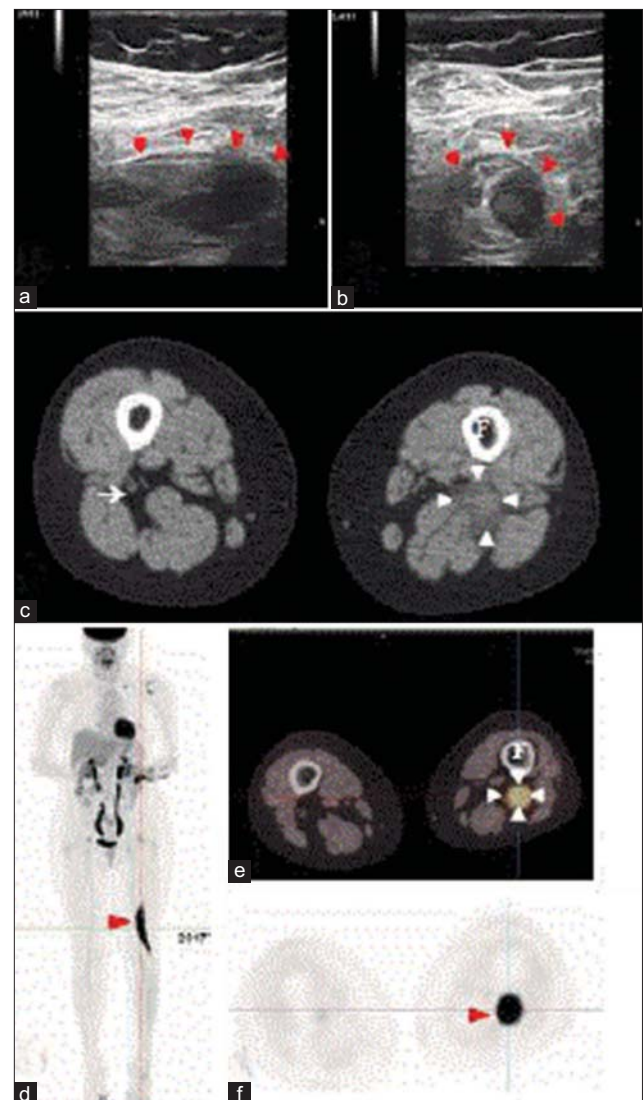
Images from a 64-year-old female with recurrent diffuse large B-cell lymphoma involving sciatic nerve mononeuropathy. Transverse (a) and longitudinal (b) sonographic images presented as a large heterogeneous fusiform mass (arrowheads) in the deep posterior thigh. (c-f) Positron-emission tomography/computed tomography images [(d) coronal view; (c, e, f) axial view] showing intense fluorodeoxyglucose uptake in a mass (arrowheads) infiltrating and compressing the sciatic nerve, corresponding to a swollen muscle (likely the biceps femoris muscle). Findings for the right thigh were normal (arrow). F: Femur
